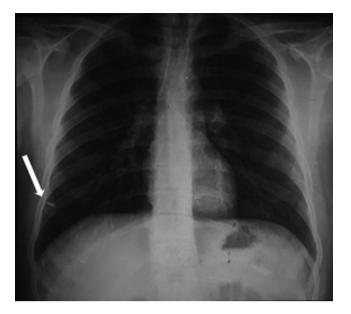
Chest X-ray view: intrathoracic needle (white arrow)
